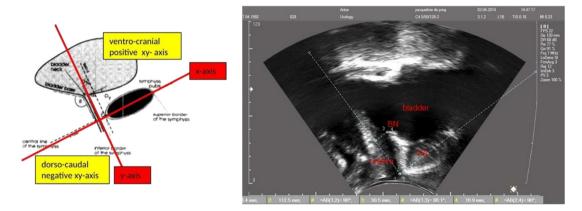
Left: Measurement perineal ultrasound: D_{χ} : distance between the γ-axis and bladder neck, D_{γ} : distance between the χ-axis and bladder neck (adapted from G. Schaer) Right: Displacement of the bladder neck during a cough in crook laying position. Bladder neck (BN) location was determined using the x-axis coinciding with the longitudinal axis of the pubic bone (PB) and y-axis intersecting at the inferior margin of the pubis.
